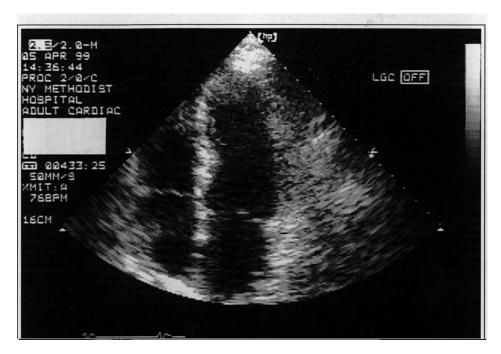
Four-chamber view of echocardiogram a week later with disappearance of the thrombus. Left ventricular function was now near-normal.
